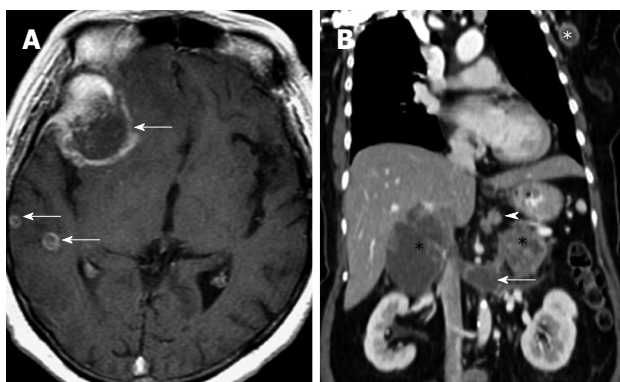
Computed tomography images of a patient with metastatic neuroendocrine carcinoma. A: Axial T1 weighted fat-suppressed image of the brain in a patient with metastatic neuroendocrine carcinoma. Multiple ring enhancing lesions (arrows) are present in the right cerebral hemisphere, consistent with metastases. The dominant lesion in the right frontal lobe was hemorrhagic; B: Reconstructed contrast enhanced computed tomography image of the same patient in the coronal plane shows multiple sites of metastases: perigastric nodes (arrowhead), bilateral adrenal glands (black *), extension into the left renal vein (arrow) and a left axillary lymph node (white *). The primary lesion is believed to have originated from the stomach, which presented as an ulcerated mass on endoscopy (not shown).
